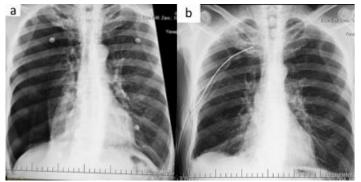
Chest x-ray before (a) and after (b) of the patient
